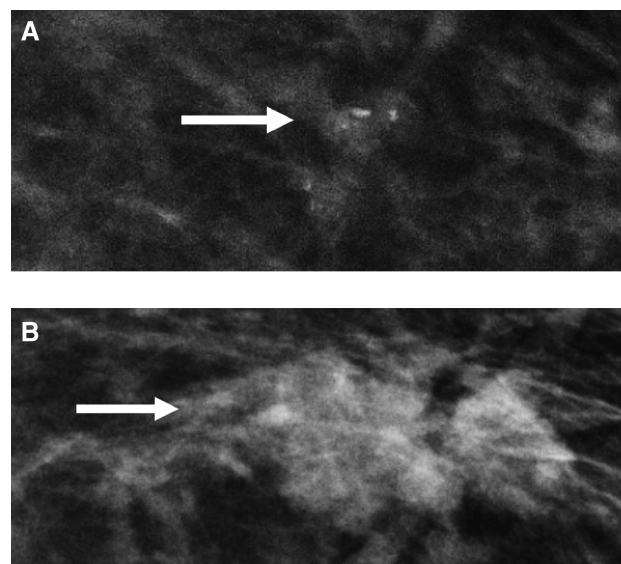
55-year-old woman with grouped coarse heterogeneous calcifications in her left breast on screening mammogram, left craniocaudal view (A) (arrow). The calcifications were not investigated. The patient presented for screening three years later as per standard of care in the United Kingdom, where the mammogram (B) was performed. An irregular mass with spiculated margins (arrow) is now seen at the site of the calcifications, which are no longer visualized. US-guided core-needle biopsy was performed of a sonographic correlate (not shown), yielding grade 2 invasive ductal carcinoma (ER+, PR+, HER2-). It is not possible to know if the unbiopsied calcifications represented ductal carcinoma in situ, but this is a plausible scenario.
